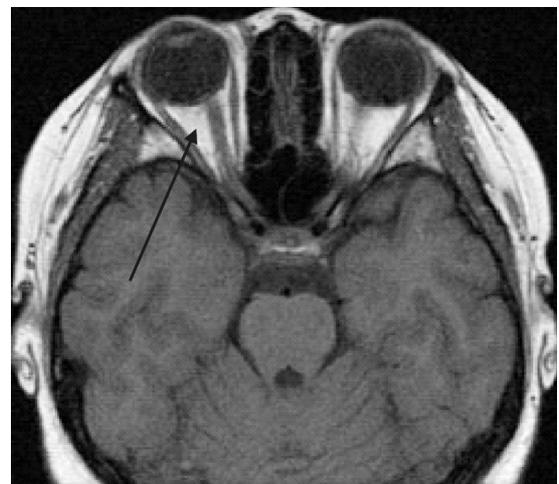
MRI of the brain and orbit showing a thickened right optic nerve
